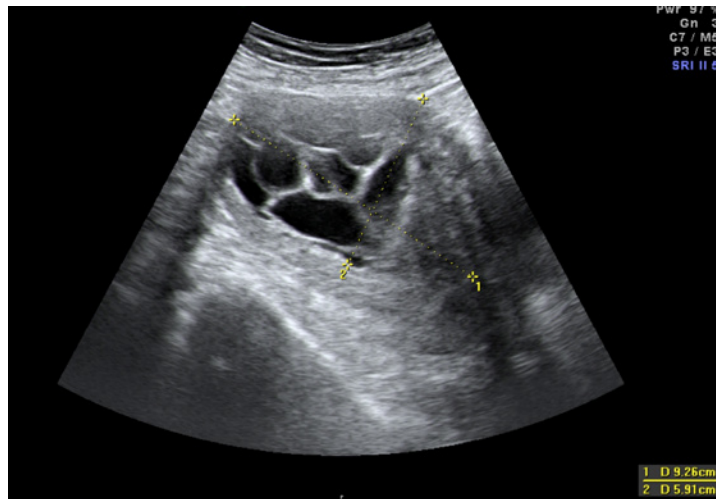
(a) Ultrasound showing a cystic degeneration of a fibroid
